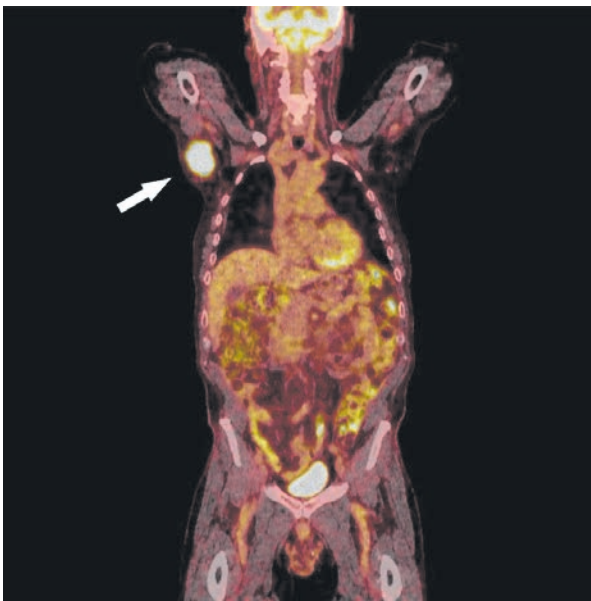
FDG-PET-CT of a DLBCL patient, pathological glucose accumulation in right armpit (arrow)
